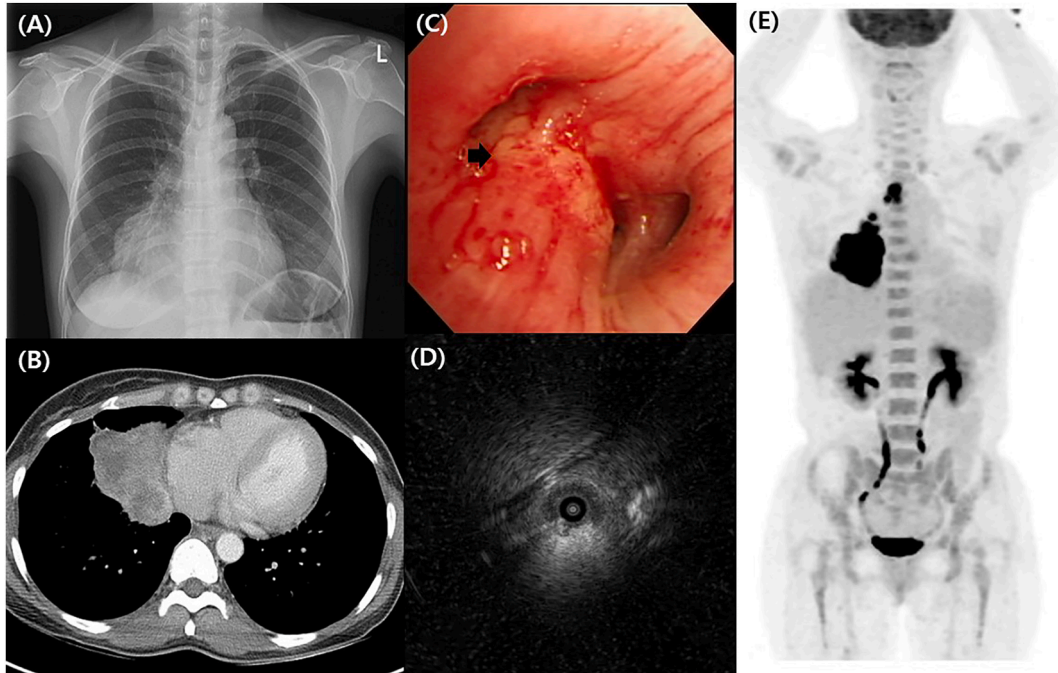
Initial diagnosis. (A) The chest radiograph showed a protruding mass over the right cardiac border. (B) The chest CT showed a 7.6 cm sized huge mass in right middle lobe. (C) Bronchoscopy showing the protruding lesion at bronchus intermedius (black arrow). (D) Radial probe endobronchial ultrasound showed hypoechoic lesion in right lower lobe basal segment. (E) Findings of fluorine-18 fluorodeoxyglucose (^{18}F -FDG) PET-CT showed dense uptake of ^{18}F -FDG in the lung mass in the right middle lobe (maximum (standardized uptake value, [SUV]; SUVmax 35.86) and ^{18}F -FDG uptake in enlarged right paratracheal and hilar lymph nodes (SUVmax 11.16). The PET-CT did not show the FDG uptake in bone marrow or bone. CT, computed tomography; PET-CT, positron emission tomography-CT.
